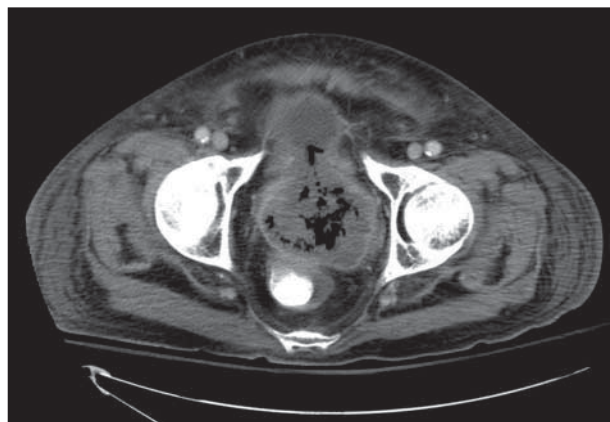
Axial computed tomographic image demonstrating a large necrotic pelvic mass involving the prostate and urinary bladder, with air resulting from an indwelling Foley catheter.
